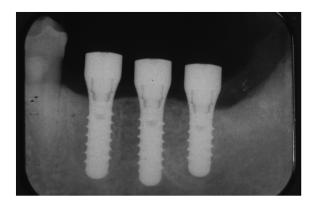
Radiograph shows good radiodensity surrounding three implants placed (location: teeth #18 through #20). The x-ray was taken right after implant placement.
